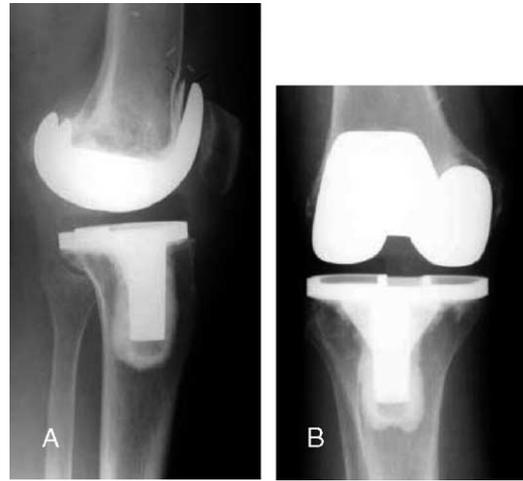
A, Lateral x-ray demonstrating lift-off of the anterior flange of the femoral prosthesis because of loosening with little evidence of osteolysis on the femur or the tibia. B, Anteroposterior x-ray demonstrating mild osteolysis along the medial femoral condyle and proximal lateral tibia.
